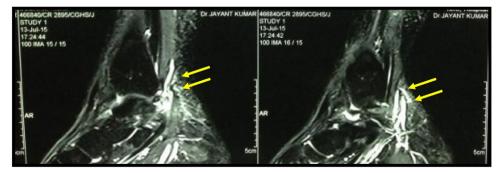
MRI showing FHL tendinitis (arrow).
